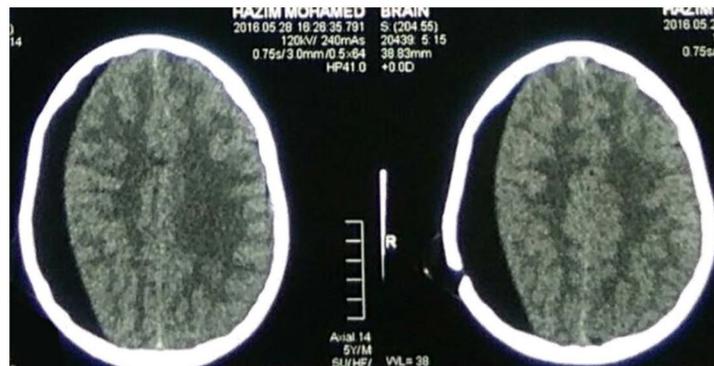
Non-contrast CT brain showing recurrent Rt cerebral crescent-shaped subdural hygroma.
